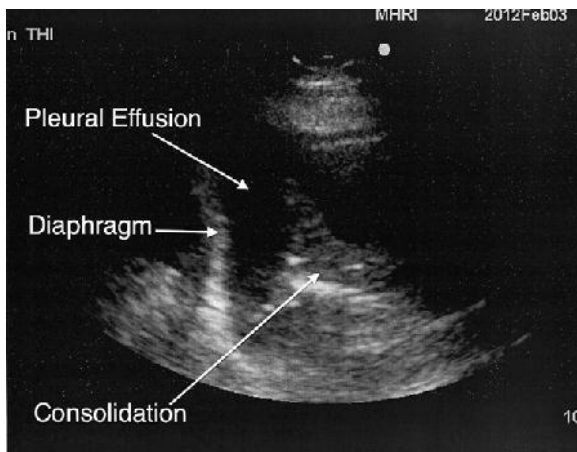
Ultrasound image of the lung depicts the diaphragm, a pleural effusion, and an infiltrate.
